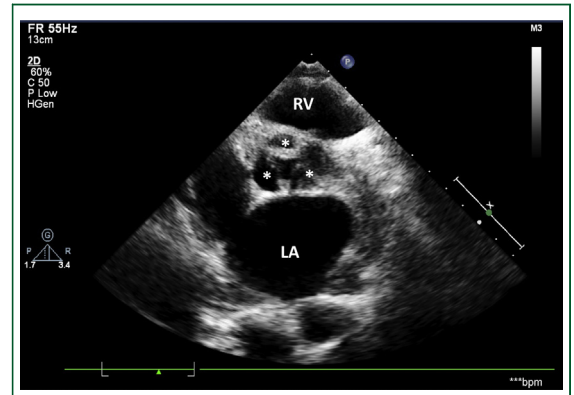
Parasternal short-axis view showing thick aortic valve with 3 cusps (*) in a patient with rheumatic aortic stenosis. Abbreviations as in Figures 1 and 2.
